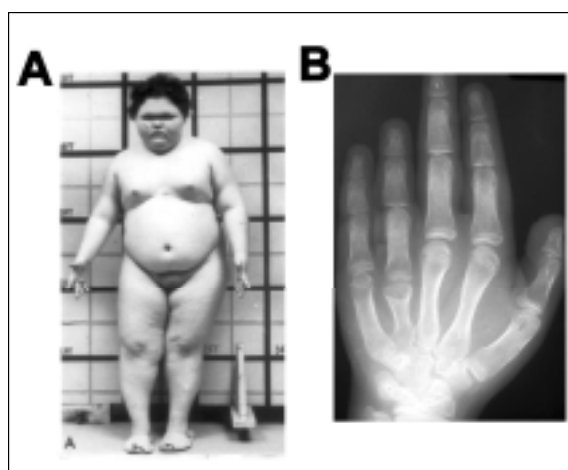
Features of AHO. A. Photograph of AHO patient showing obesity, rounded face, and short stature. B. Hand radiograph showing brachydactyly of the 4th metacarpal bone.
